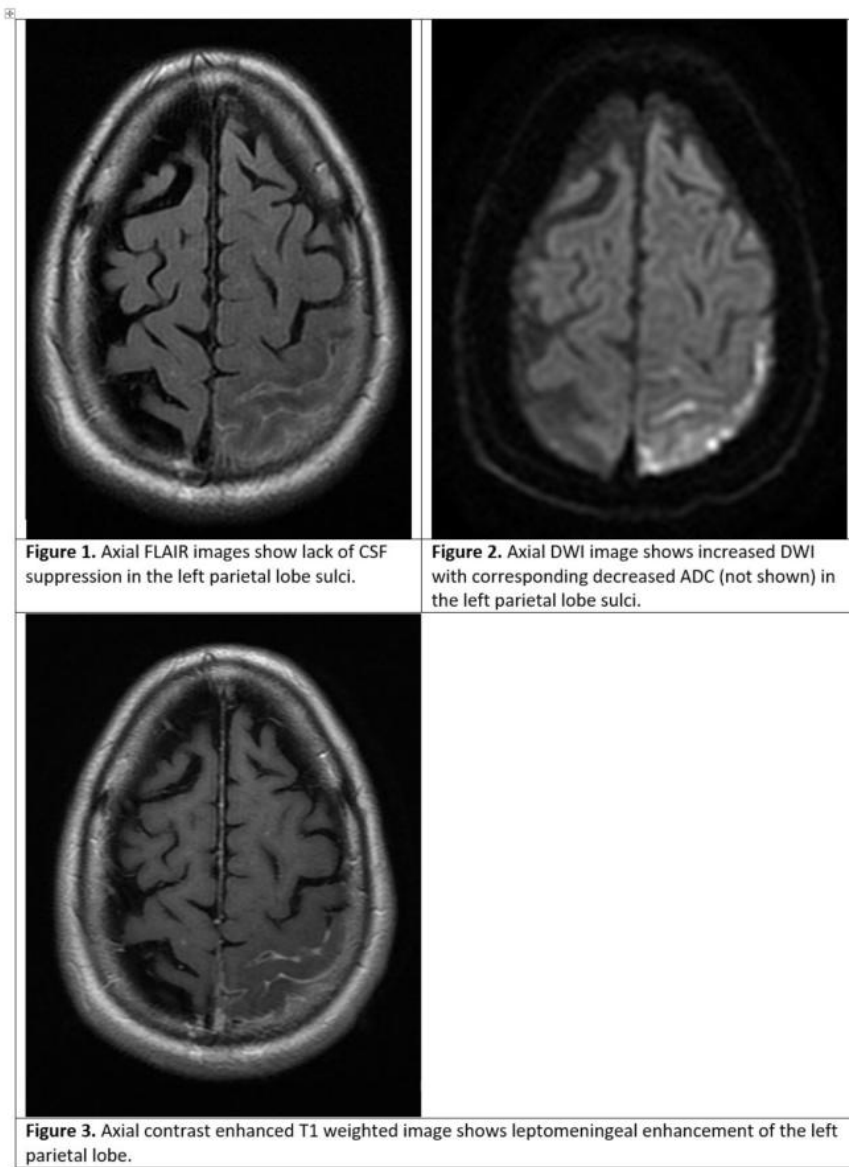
Axial FLAIR images show lack of CSF suppression in the left parietal lobe sulci.
